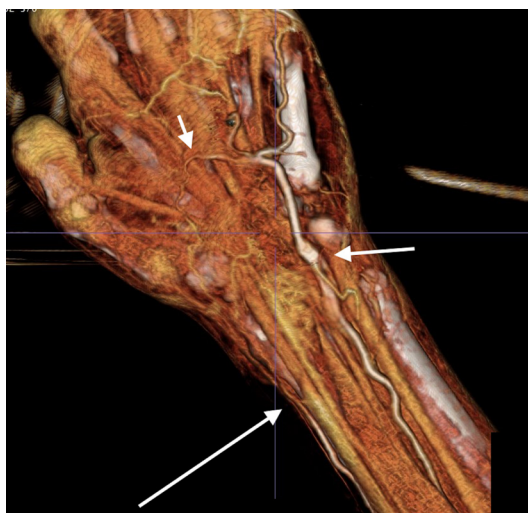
Three-dimensional reconstruction of left upper extremity CT angiography. The radial artery (long arrow) is obstructed and the ulnar artery (short arrow) is hypertrophied. There is poor flow through the superficial palmar arch (arrowhead).
